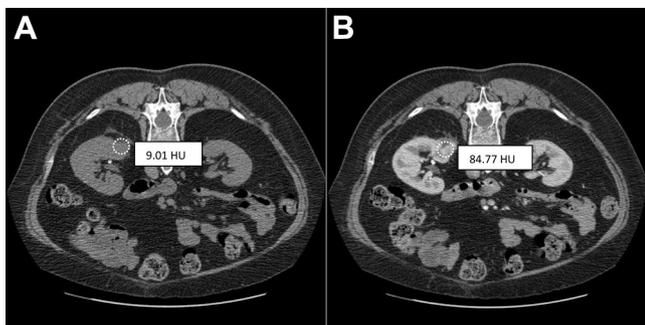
Measuring kidney tumor enhancement using region of interest to determine HU in noncontrast phase CT (A) and arterial contrast phase CT (B).
